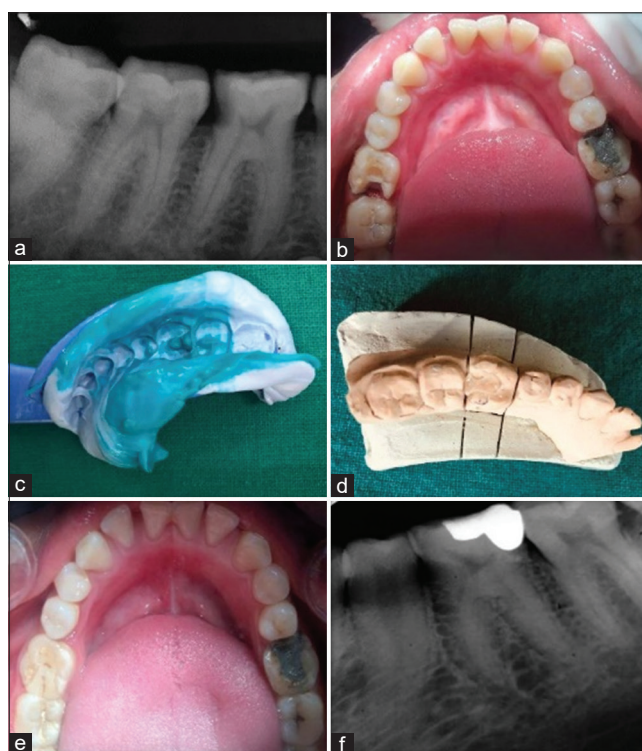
(a) Pre-operative radiograph (b) cavity preparation (c) polyvinyl impression (d) cast (e) post-operative picture (f) post-operative radiograph
